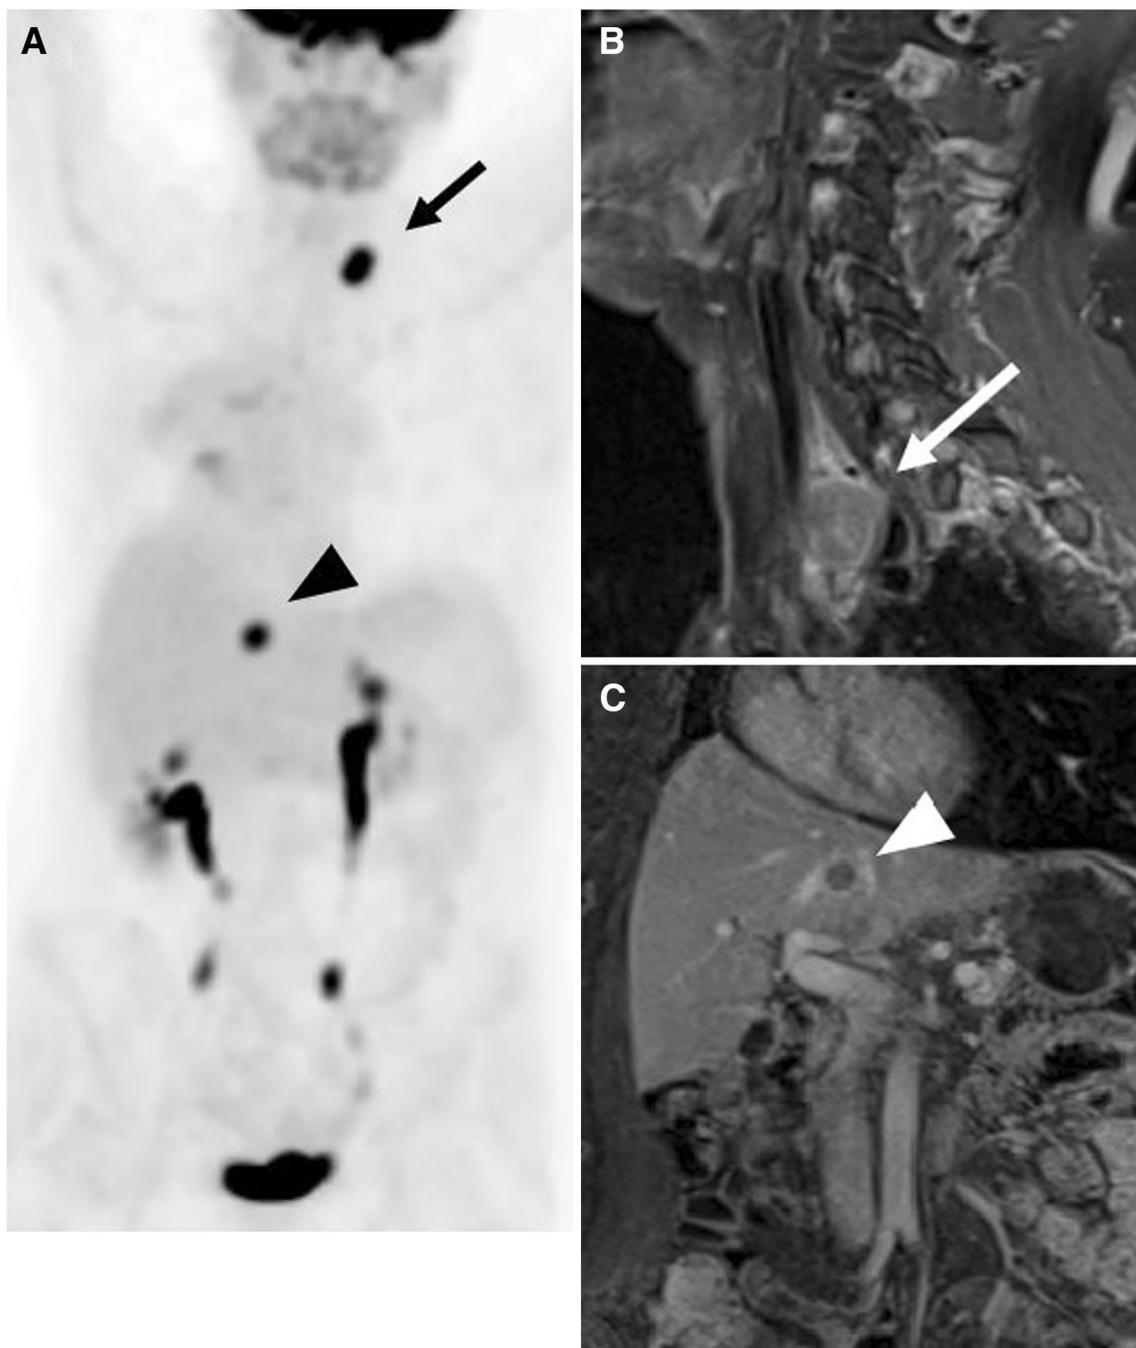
57-year-old woman with stage II B high grade squamous cell cervical carcinoma initially treated with chemoradiation. A Follow-up PET shows hypermetabolic lesions in the liver (arrowhead) and supraclavicular region (arrow). B Sagittal T1-weighted contrast-enhanced MRI
